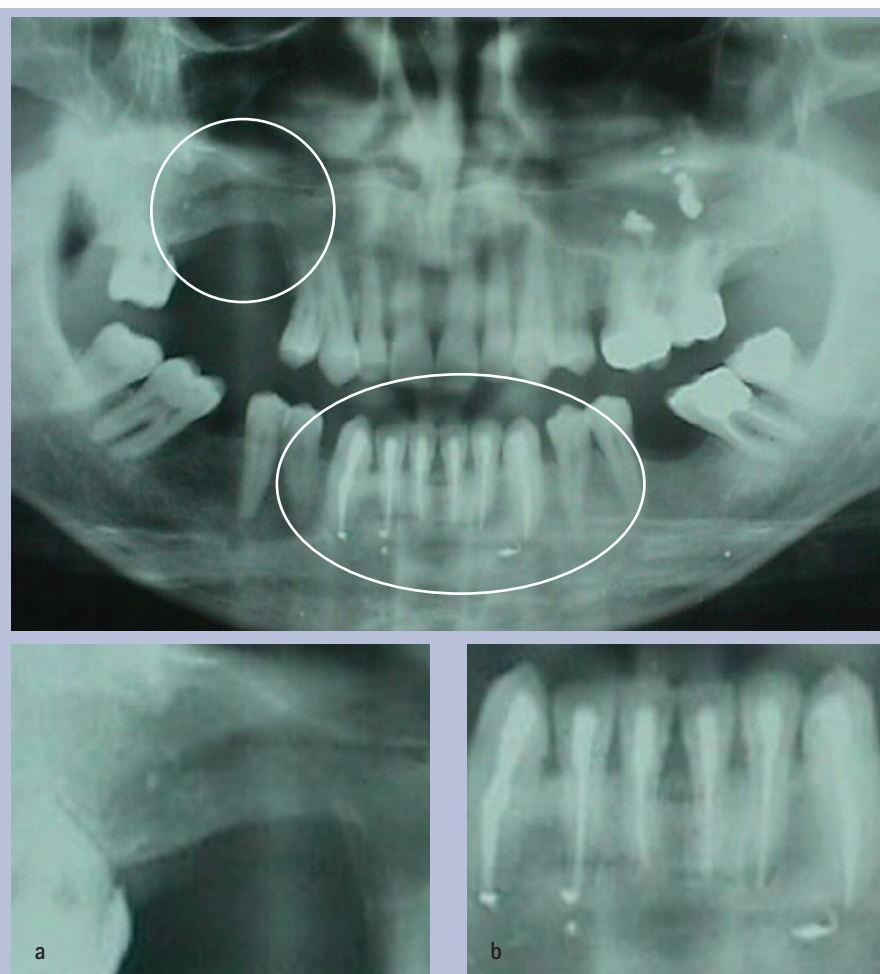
Post-operative panoramic radiograph showing detail of the after effects associated with acute purulent maxillary sinusitis by *Pseudomonas aeruginosa*, secondary to autologous bone transplant for dental implants: a) lowering of the right orbital floor; b) pulpal necrosis of six dental elements (positions 43–42–41–31–32–33)
